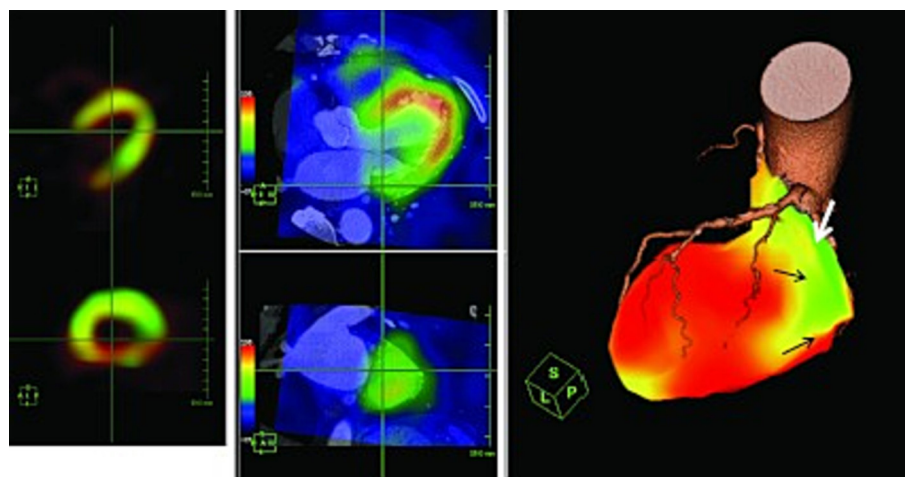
Right Image: The white arrow indicates a region of 99% stenosis (CT scan) and black arrows an area of reduced perfusion as highlighted from SPECT image (Jinzaki et al., 2011).
